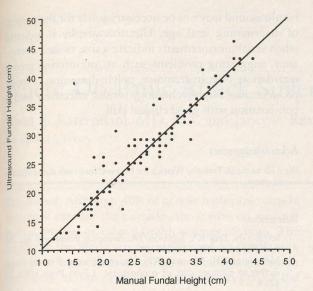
Comparison of manual and ultrasound measurements of fundal height in 119 patients.
